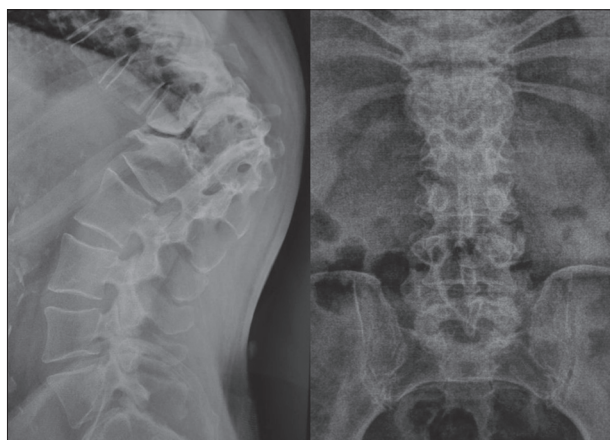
X-ray of the spine showing severe kyphosis at the thoracolumbar junction
